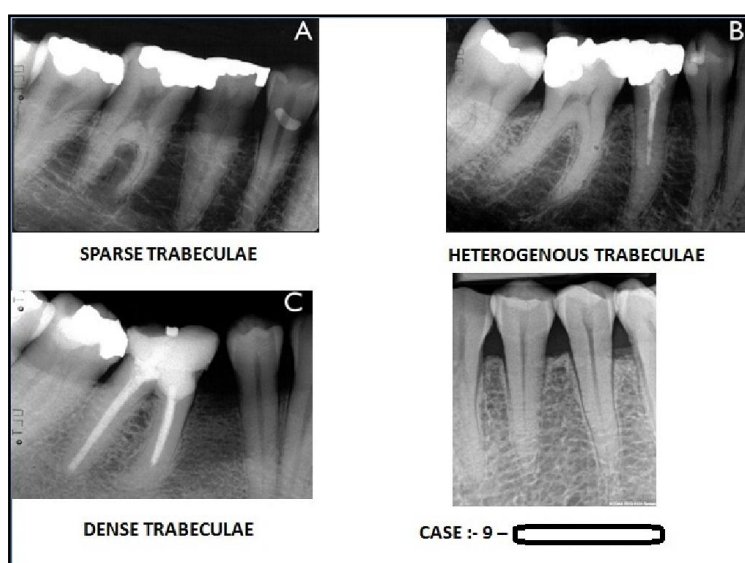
The screenshot showing that the patient direct digital intraoral periapical radiograph is compared with the reference radiographs by the observers to evaluate the different trabecular pattern
